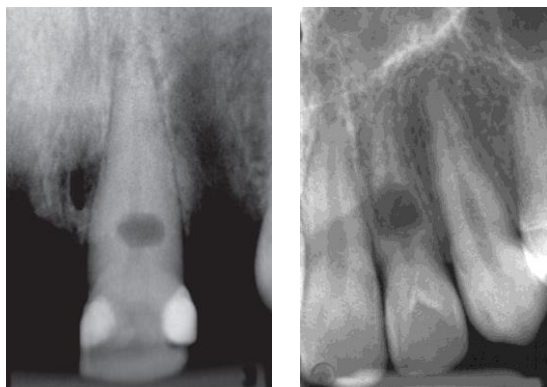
Radiograph showing internal root resorption. (a) radiolucent oval shape with relation with root canal suggestive of IRR; (b) An extensive radiolucency starting from inside the tooth and extending to the outer surface of the tooth suggesting a pathological perforation caused by the severe IRR
